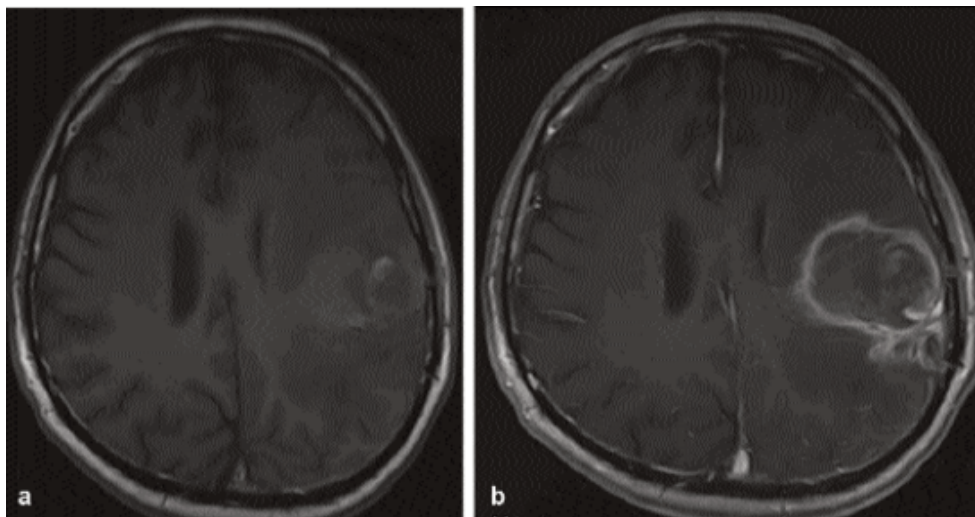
(a,b) 6-month follow-up MRI T1W pre and post-contrast axial images, showing recurrence of disease at the site of surgery.
